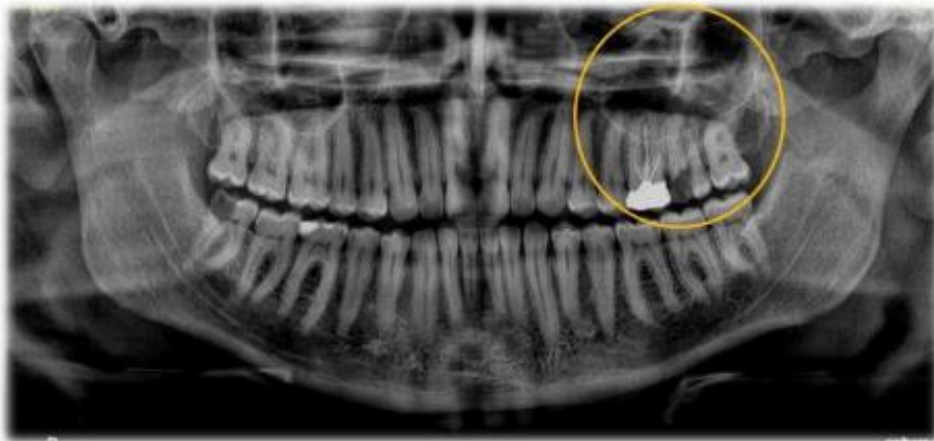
Panoramic radiograph (OPG) reveals a severely decayed left maxillary second molar and increased radiodensity in the adjacent sinus region, suggestive of sinusitis.
